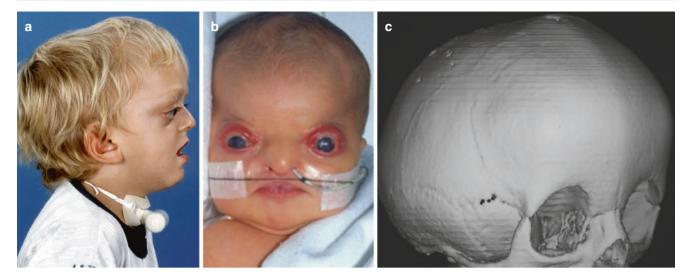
(a) Picture of face from side, showing characteristic facies with exorbitism and midface hypoplasia. (b) Neonatal diagnosis of Crouzon Syndrome. (c) 3D CT head showing pancraniosynostosis
